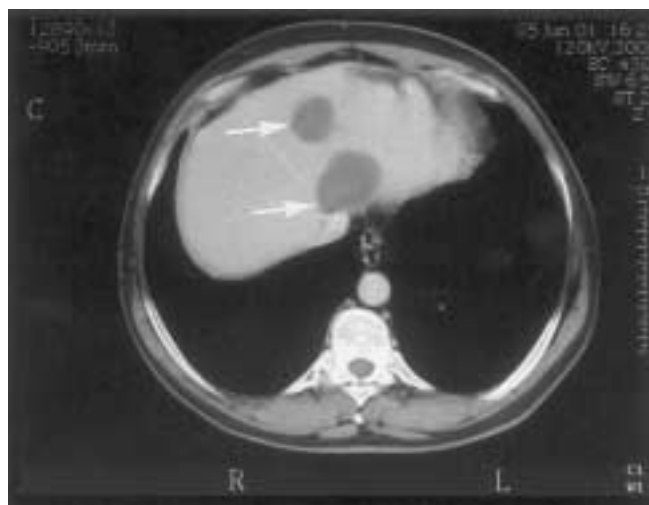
Arterial phase spiral CT pre-RFA (arrows). Laparoscopic RFA under ultrasound Post-RFA follow-up CT demonstrates the two lesions (arrows) totally hypoechoic, non-enhancing, consistent with total necrosis.
